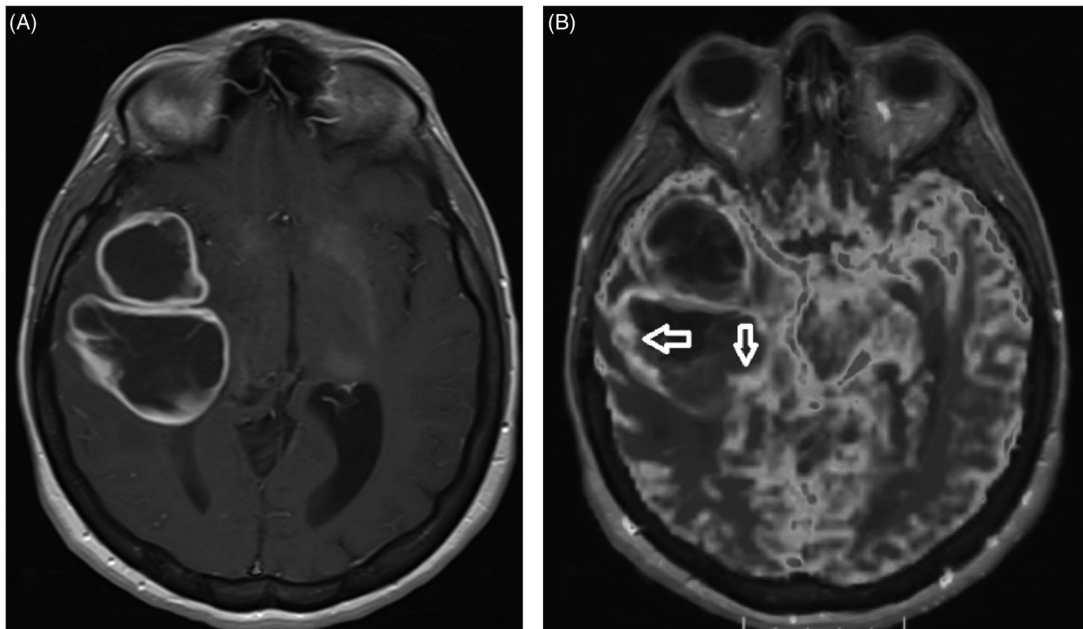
(A) Axial post-contrast T1-weighted imaging shows peripheral ring-like enhancement in cystic lesions, (B) color-coded perfusion map (overlaid on the corresponding post-contrast T1-weighted image) conducted for the area of enhancement shows increased relative cerebral blood volume (rCBV) values indicating increased vascularity (arrows).
